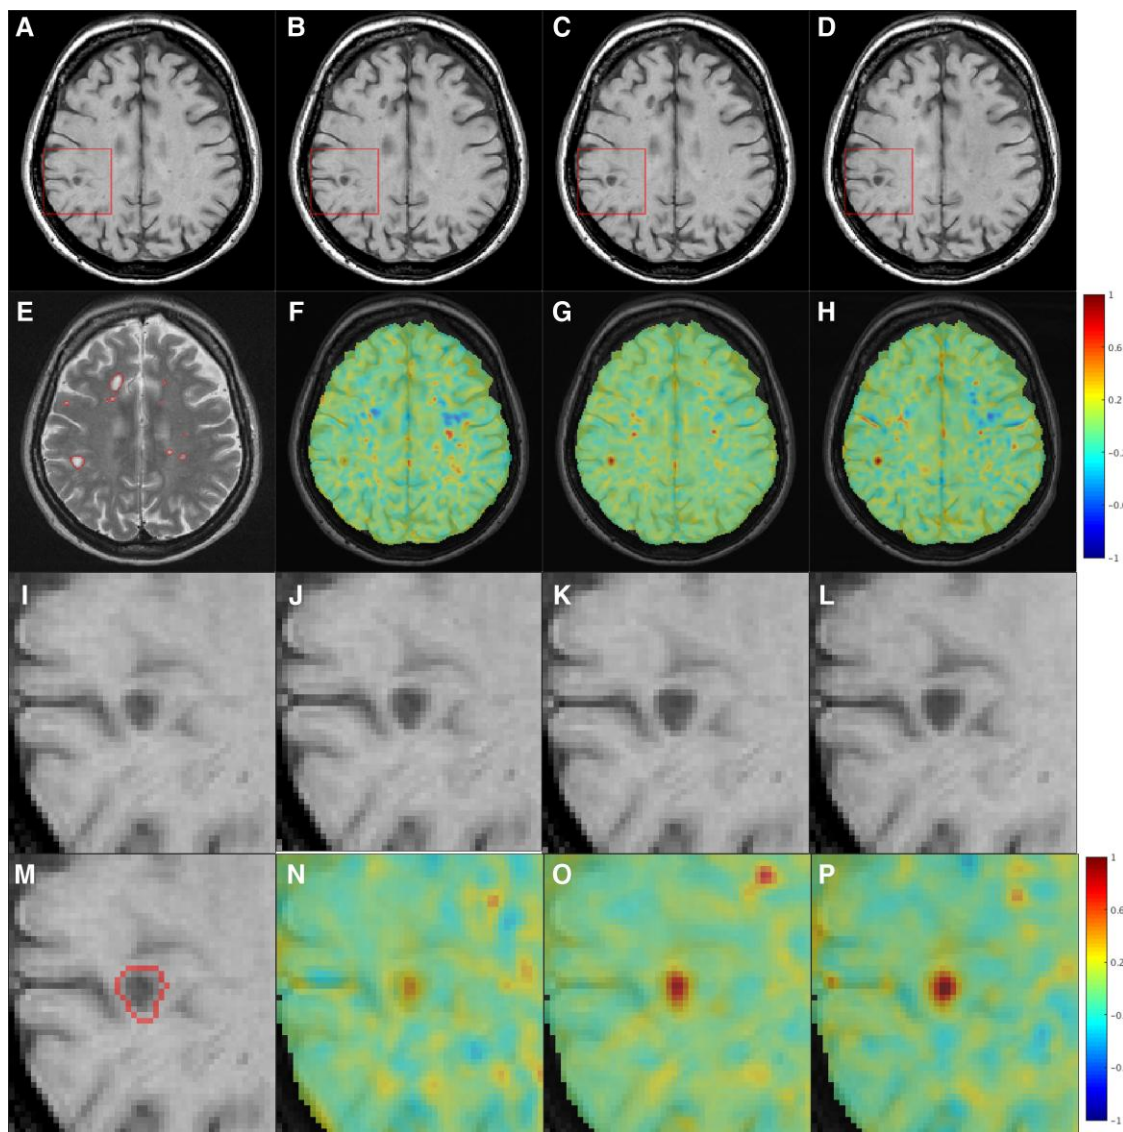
MRI-defined slowly expanding lesions (SELs). (A) Axial slice of T₁-weighted MRI at baseline; (B) 6 months; (C) 12 months; (D) and 24 months; and (E) T₂-lesion mask of baseline scan. (F) Jacobian determinant maps at 6 months, (G) 12 months and (H) 24 months, all with respect to baseline, where values >0 (red) indicate expansion and values <0 (blue) indicate shrinkage. A region of interest corresponding to red box in A–D, at baseline (I), 6 months (J), 12 months (K) and 24 months (L). In M the lesion area, identified as SEL, is contoured. Jacobian determinant maps in region of interest at 6 months (N), 12 months (O), 24 months (P), all with respect to baseline, showing the gradual expansion over time. Image contributed by Dr Colm Elliott.
